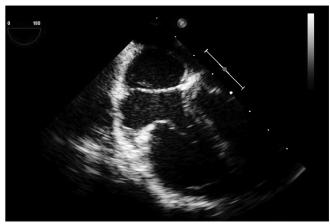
2D transoesophageal echocardiography apical four chamber view showing presence of a membrane separating the right atrium into two parts
